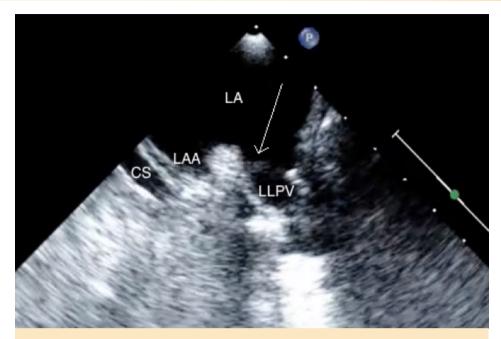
Transesophageal echocardiogram: mid-esophageal view demonstrating thrombus at the origin of the left lower pulmonary vein (white arrow). LLPV: left lower pulmonary vein, LA: left atrium, LAA: left atrial appendage, CS: coronary sinus
